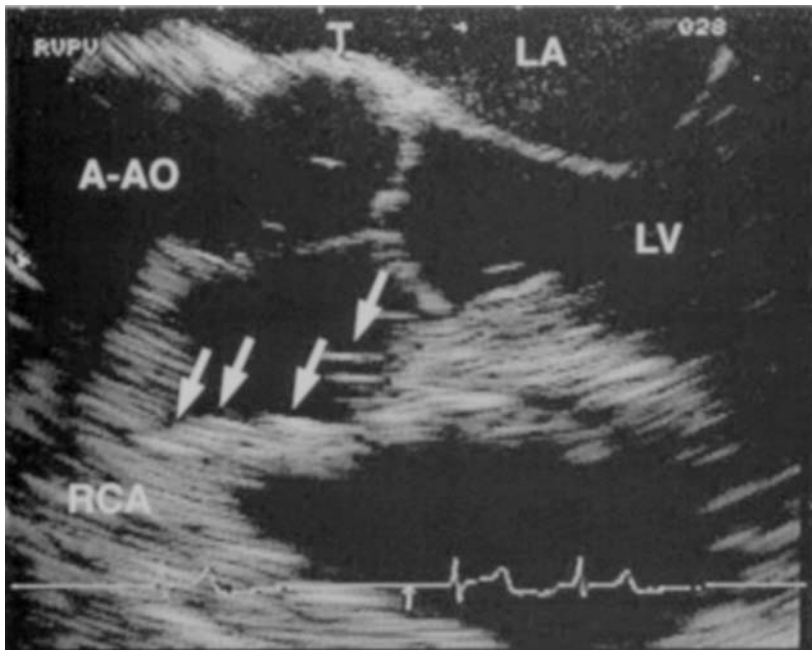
Transoesophageal echocardiogram showing air entering the right coronary artery (RCA). A-AO = ascending aorta, LA = left atrium, LV = left ventricle.
